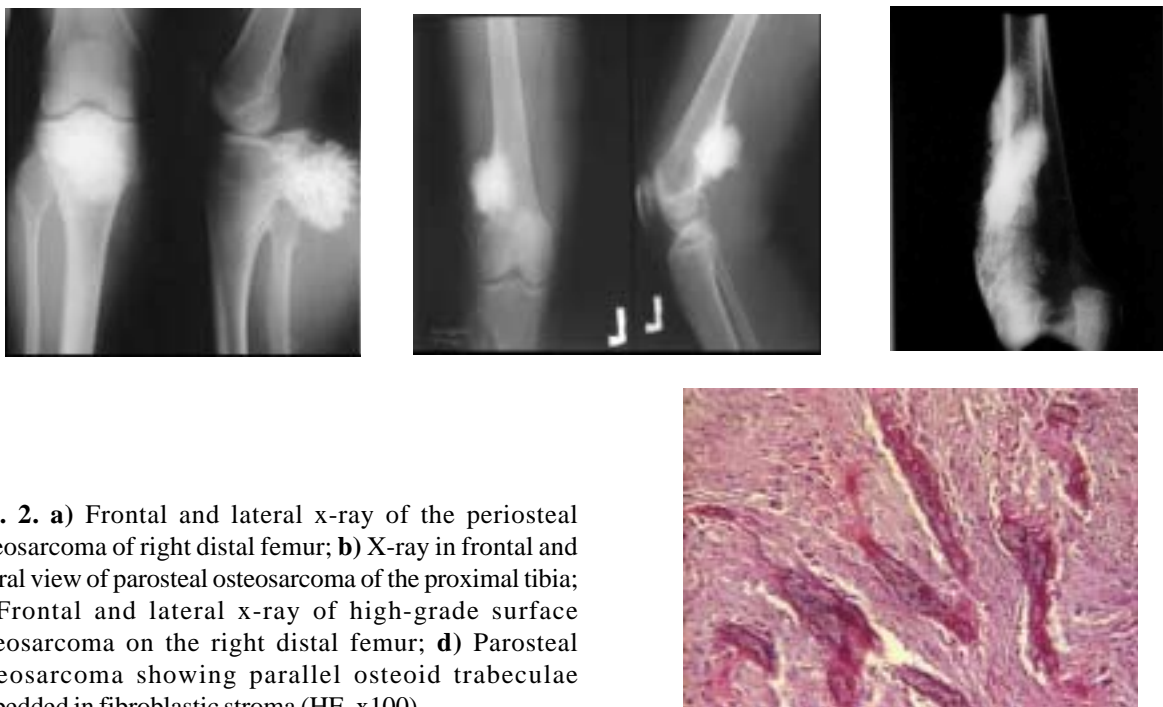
a) Frontal and lateral x-ray of the periosteal osteosarcoma of right distal femur; b) X-ray in frontal and lateral view of parosteal osteosarcoma of the proximal tibia; c) Frontal and lateral x-ray of high-grade surface osteosarcoma on the right distal femur; d) Parosteal osteosarcoma showing parallel osteoid trabeculae embedded in fibroblastic stroma (HE, x100).
